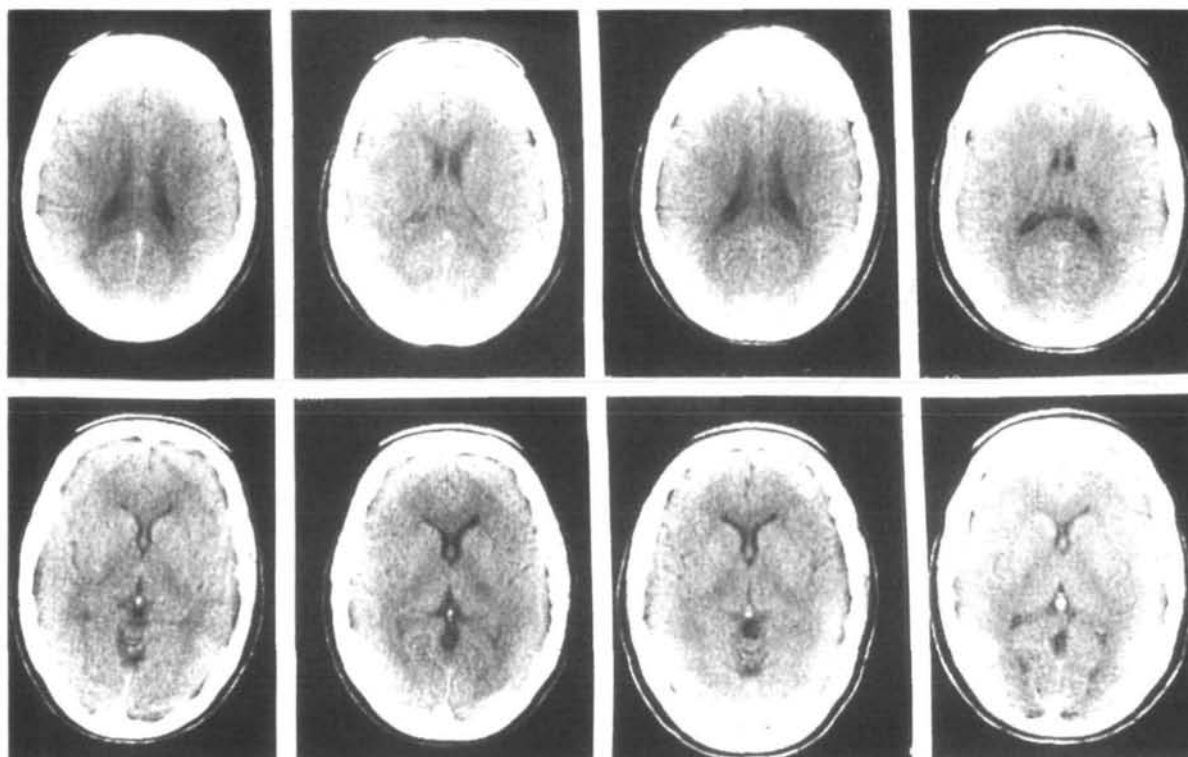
Computed tomography on Genain quadruplets
